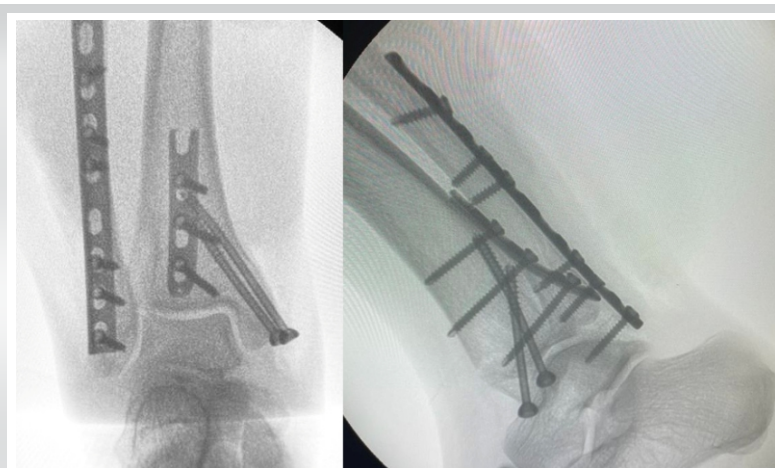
X-ray images taken in the operating room.
